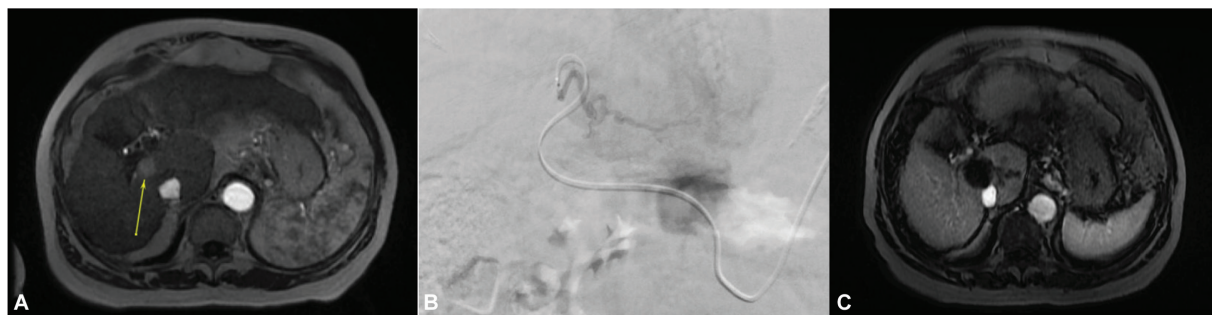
Example case of yttrium-90 (Y90)-radiation segmentectomy (RS). (A) Axial postcontrast T1-weighted image demonstrates a rounded, 1.8-cm arterial phase enhancing lesion in segment 5/1 with washout (LR-5). (B) Transradial angiogram demonstrates an enhancing mass in segment 5/1. (C) Post-Y90-RS contrast-enhanced axial computed tomography (CT) demonstrating the treatment zone of 2.9 cm diameter with no viable tumor.
